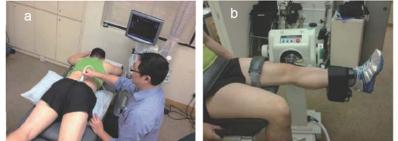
Ultrasound imaging of the lumbar multifidus activation using contralateral arm raise, b) Concentric knee extension test at 60°/s on an isokinetic dynamometer.
